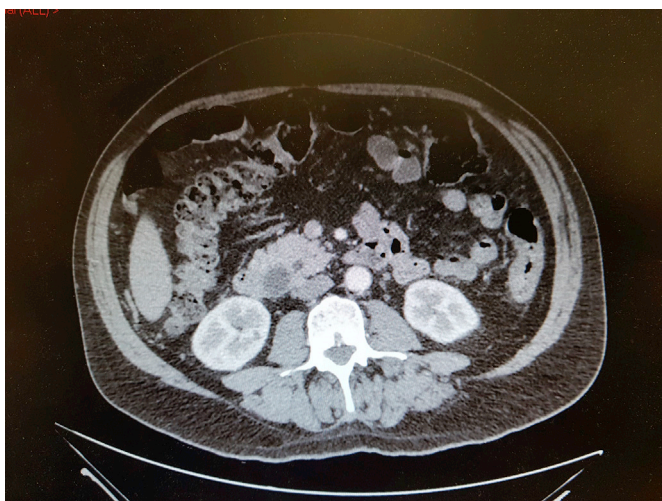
Mass in head of pancreas with preserved PV/SMV fat-plane. CT showing an ampullary mass with a clear fat plane around the SMV. This patient underwent routine pancreaticoduodenectomy.
